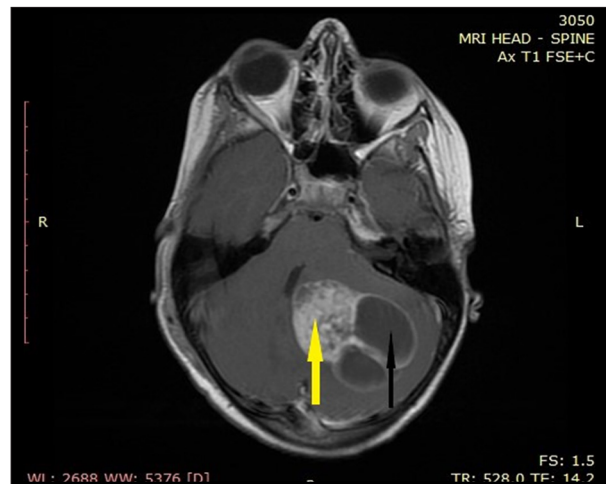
Magnetic resonance imaging (MRI) obtained prior to tumor removal, axial T1 weighted, fast spin echo (FSE) sequence following contrast administration, depicting the solid (yellow arrow) and cystic parts (black arrow) of the posterior fossa lesion.
